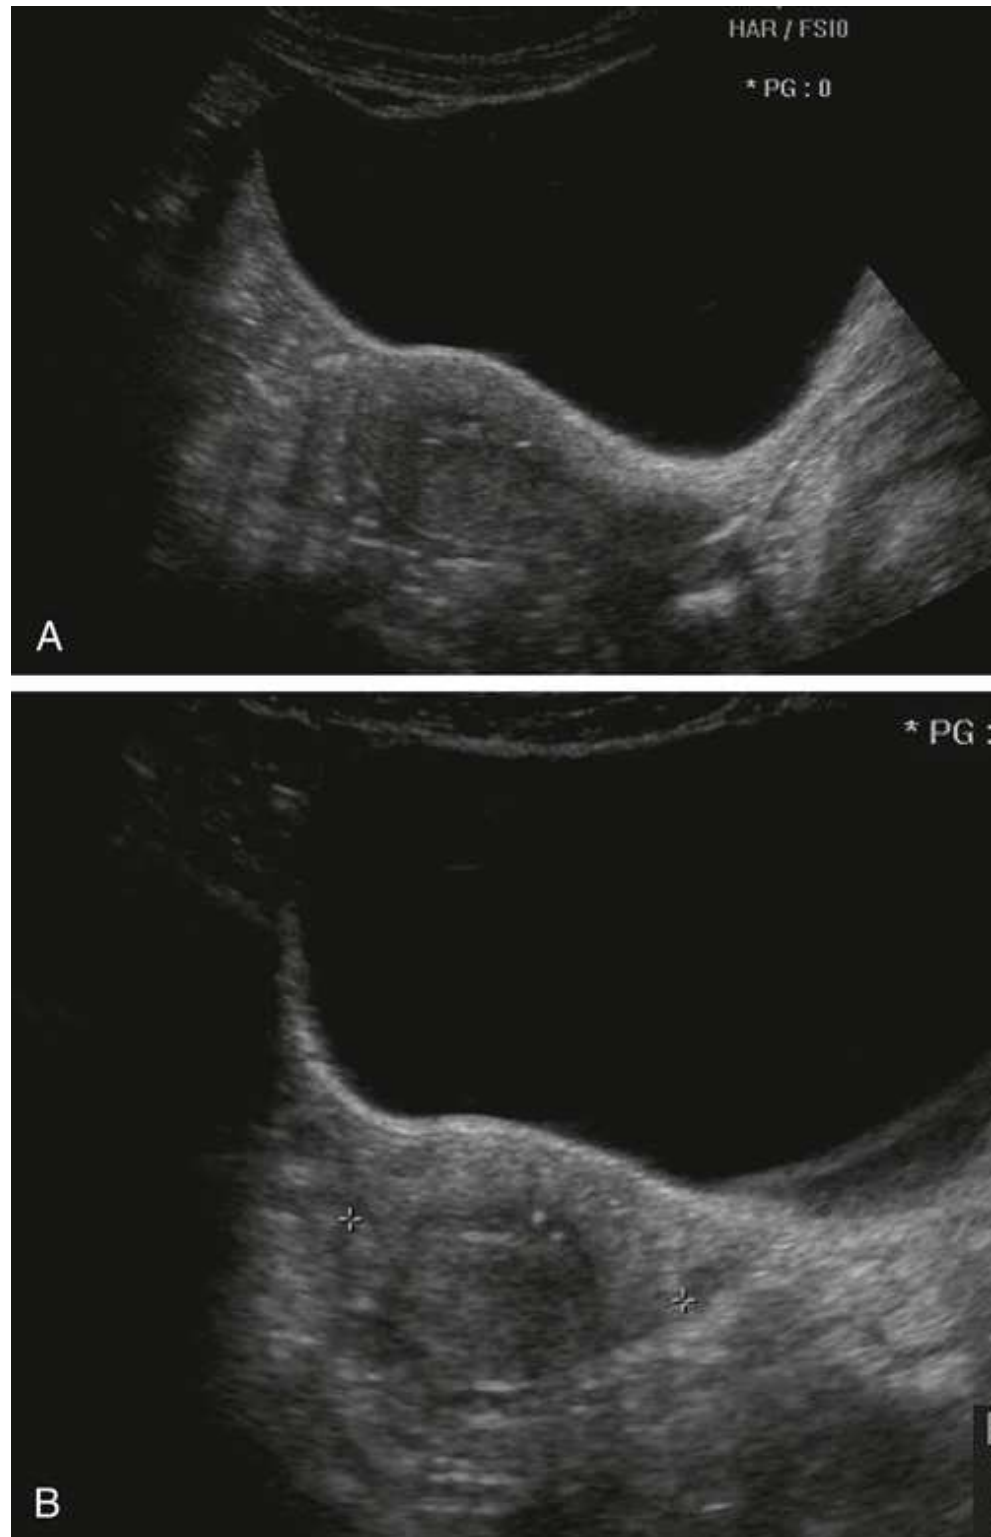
(A) Transabdominal sagittal sonogram of uterus. (B) Transabdominal transverse sonogram of uterus with measurements.
